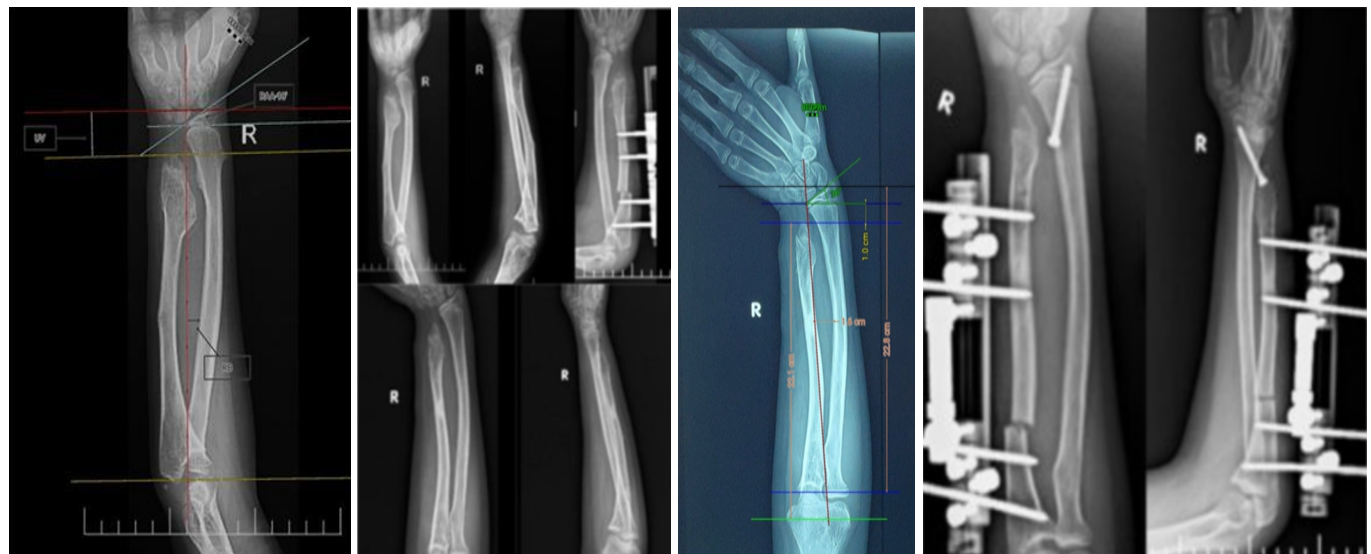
(a) Pre-operative anteroposterior, lateral radiograph Masada Type IVa deformity pattern in a 9-year-old. Increased Ulnar variance of 2.2 and radial bow percentage of 5.9, but with radial articular angle (RAA) = 18°. (b) Post-operative anteroposterior and lateral radiographs showing ulnar corticotomy with distraction osteogenesis and gradual ulnar lengthening. Eighteen-month follow-up radiographs. (c) RAA = 36° at 24 month. (d) 2nd stage corticotomy – Redo distraction osteogenesis with growth modulation for the distal radius.
